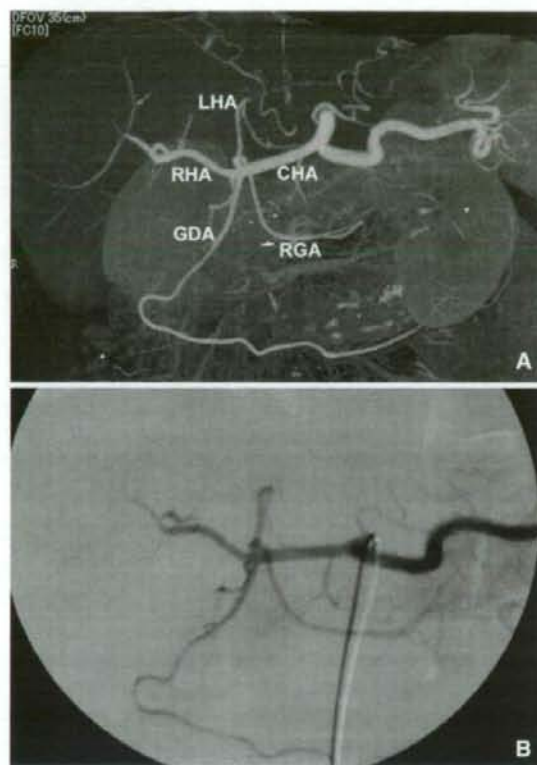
A 79-year-old man with liver metastases. A MSCTA shows the hepatic and gastrointestinal branches of the hepatic arteries. B DSA confirms the CT findings
